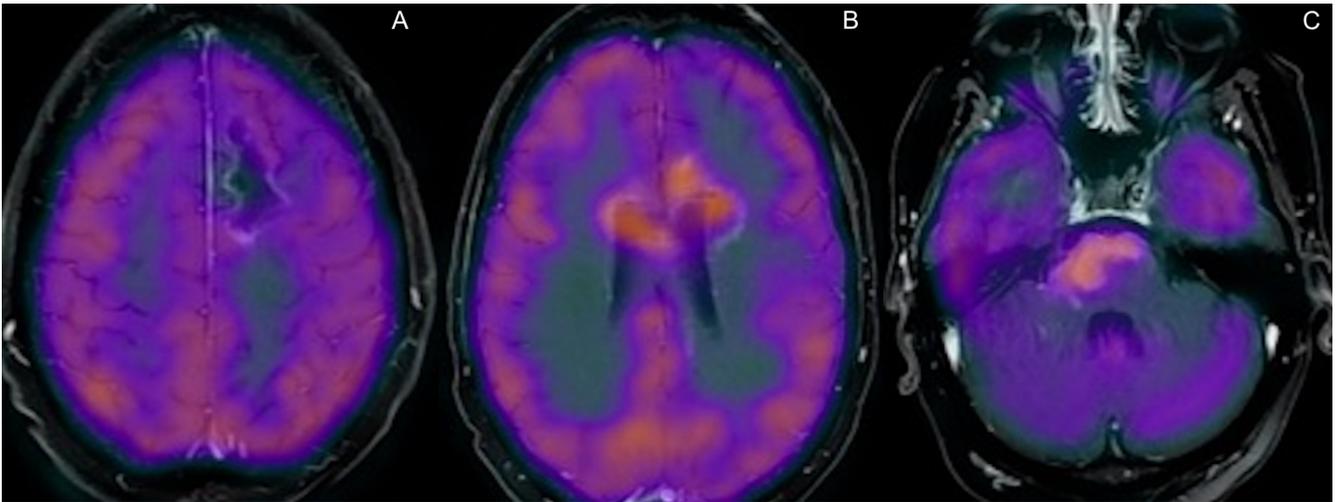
PET-CT and MRI fusion, showing the hypometabolic behavior of the original left frontal lesion (A), in contrast with hypermetabolism on the corpus callosum (B) and brainstem (C) lesions, inferring different etiologies.
